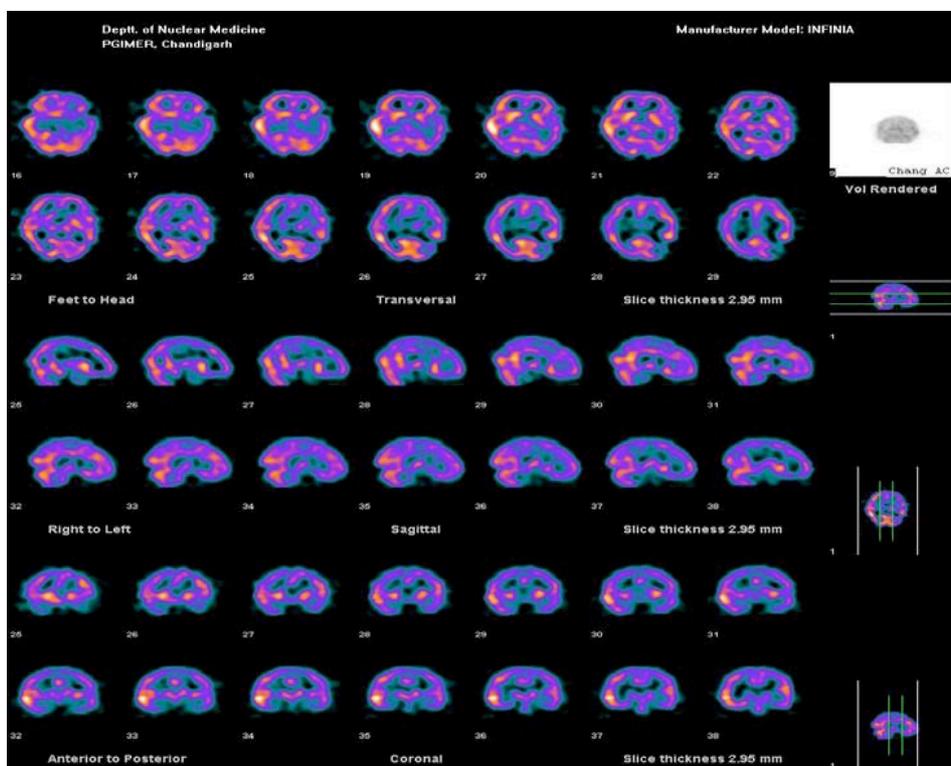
Post-operative SPECT showing severely reduced perfusion in left parietooccipital cortex.
